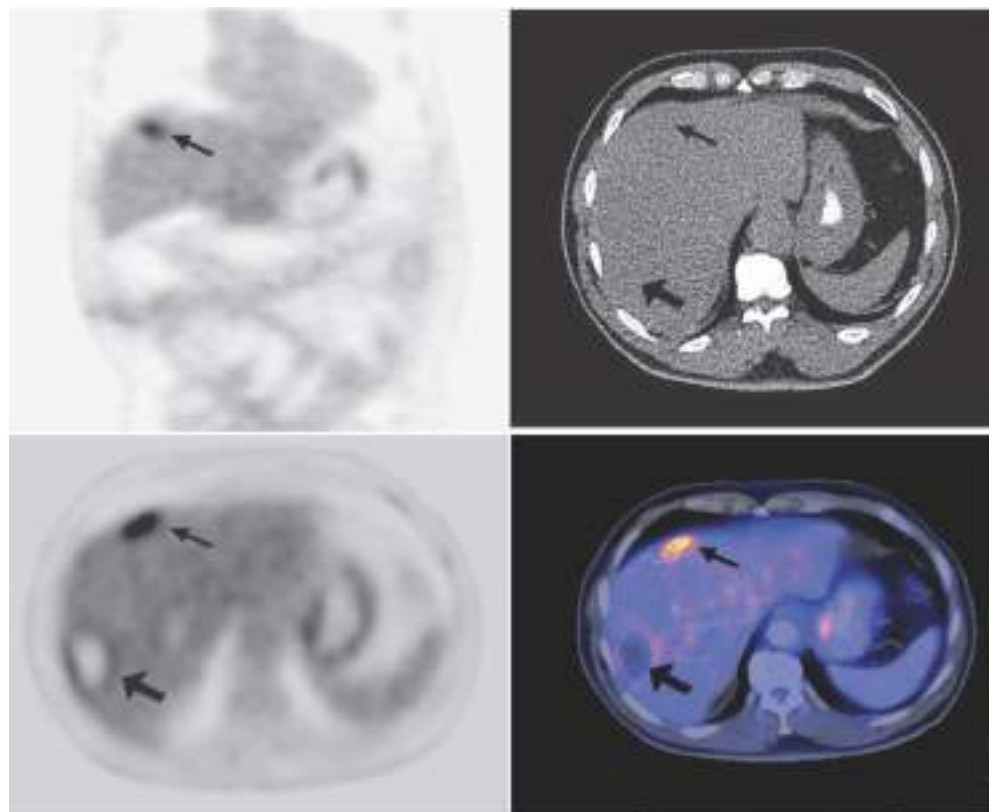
PET-CT scan and various phases. Lesions may not always show up or appear active on all phases of imaging.
